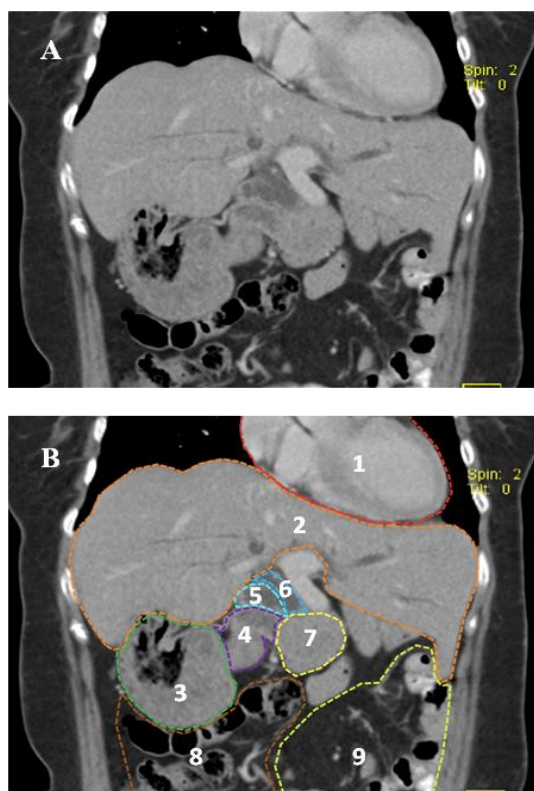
A. CT scan of whole abdomen with IV and oral contrast (coronal section). B. Coronal section labeled as follows: (1) heart with normal configuration, (2) liver at the midline, (3) stomach on the right hemiabdomen, (4) duodenum crossing the midline anteriorly to the left side, (5) partially contracted gallbladder at the midline, (6) dilated extrahepatic ducts, (7) pancreas with head located anteriorly and left of the midline, (8) large bowels on the right hemiabdomen, (9) small bowels on the left hemiabdomen.
